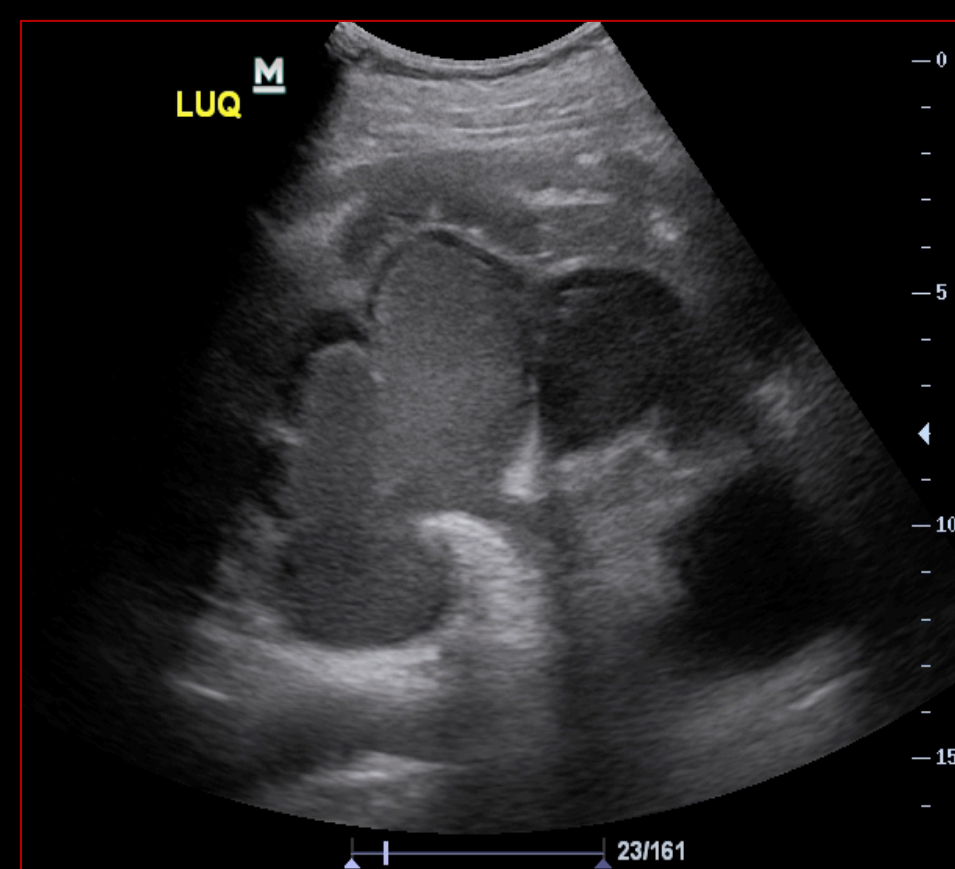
Bedside ultrasound image of Left Upper Quadrant (LUQ) showed gross hydronephrosis with heterogenous contents within the renal pyramids
